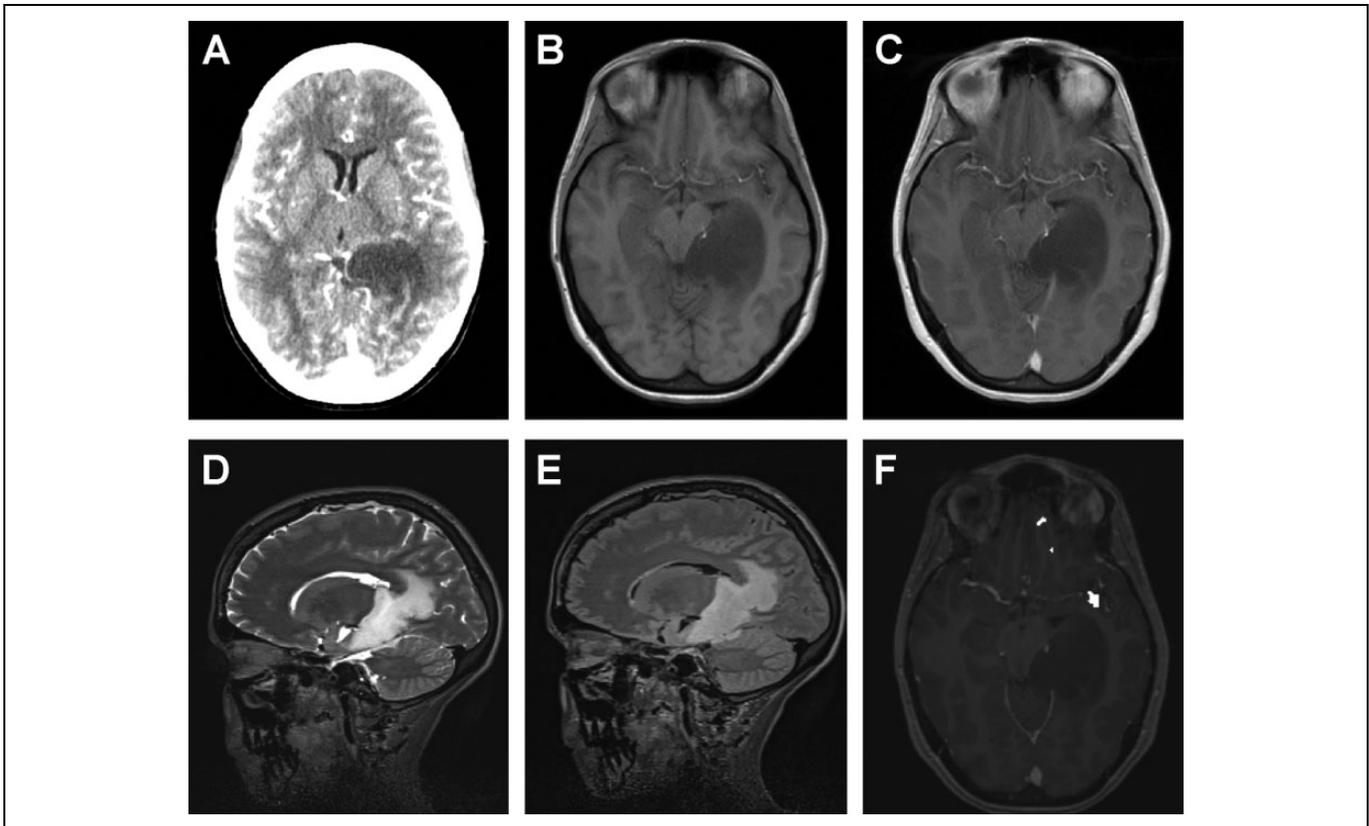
Patient 1 imaging studies. A, A right mediotemporal mass is observed on contrast computed tomography (CT) with midline shift. T1-weighted magnetic resonance imaging (MRI) demonstrates a hypointense mass (B; precontrast) that does not enhance following administration of contrast (C). Sagittal T2-weighted imaging demonstrates involvement of left temporal lobe by this hyperintense mass (D) that is less intense on fluid attenuation inversion recovery (FLAIR) imaging (E). F, The mass is hypointense on diffusion-weighted MRI.
